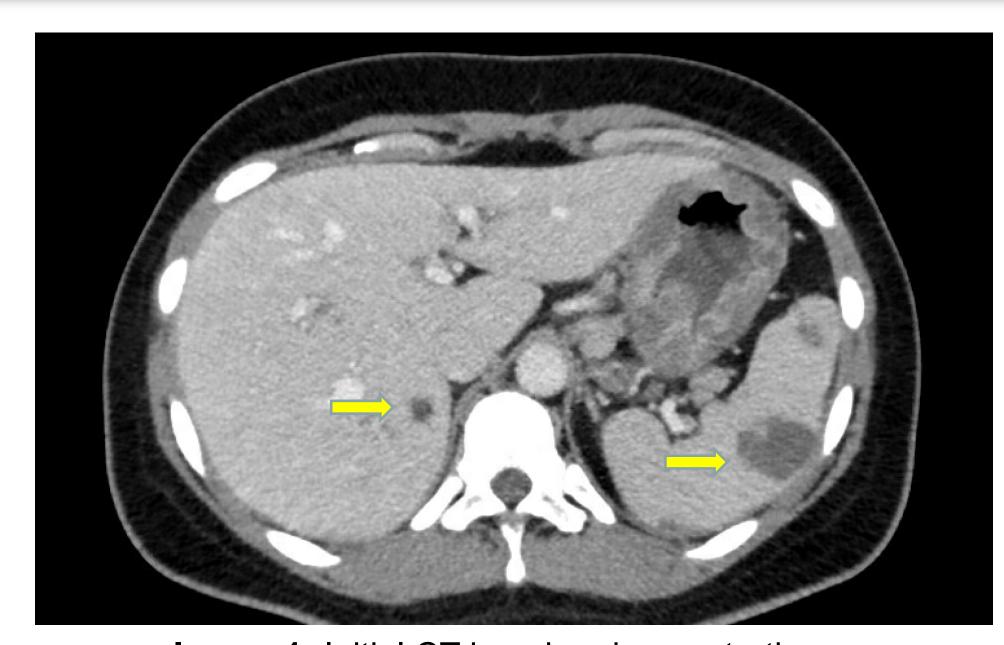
Initial CT imaging demonstrating hepatic and splenic abscesses
